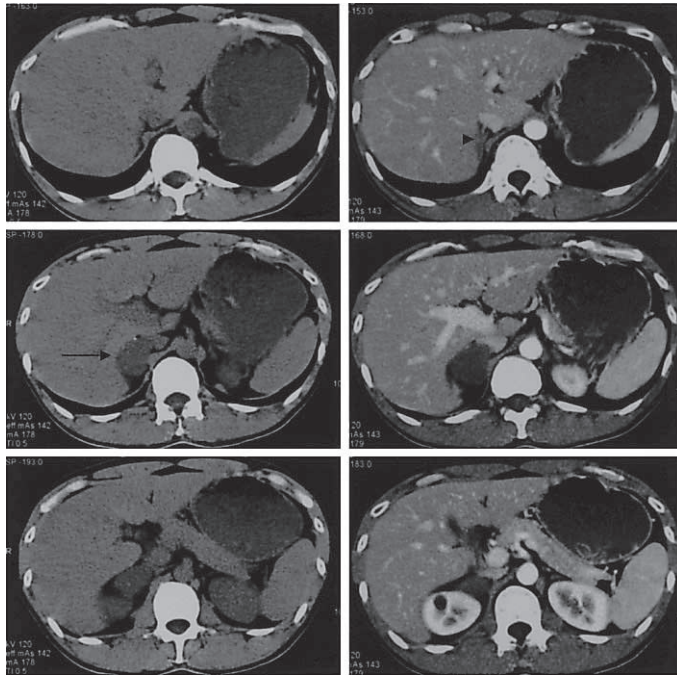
Left: plain CT, Right: contrast enhanced CT, Top: upper (top) portion, Middle: middle portion, Bottom: lower portion. Abdominal CT image showed an oval-shaped mass in the right adrenal gland (). Residual adrenal cortex was found in the top portion (). Contrast enhanced CT did not show significant enhancement effect.
